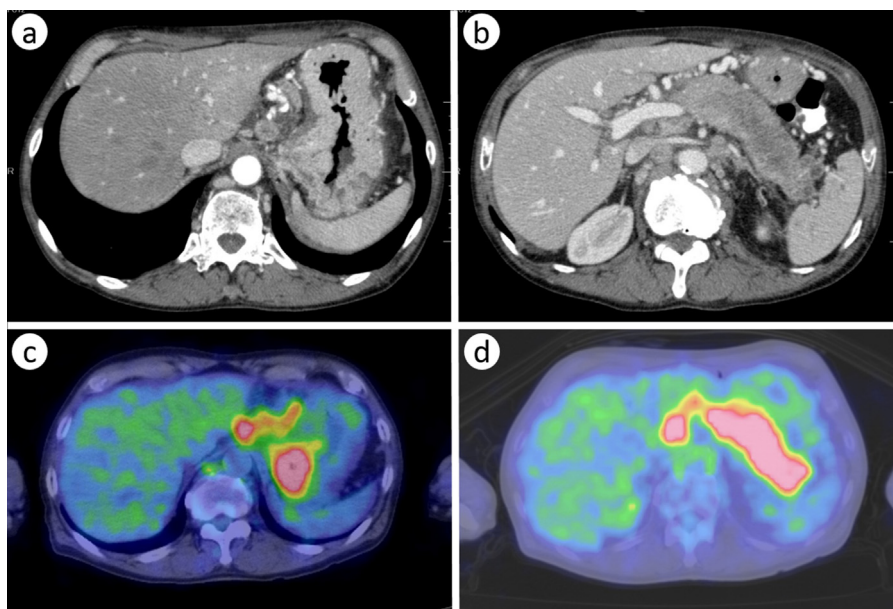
Computed tomography (CT) scan and positron emission tomography–computed tomography (PET–CT) scan using fluorodeoxyglucose (FDG). (a), An abdominal CT scan demonstrated gastric wall thickening with an enlarged perigastric lymph node; (b), An abdominal CT scan demonstrated pancreatic enlargement; (c), A PET–CT scan using FDG demonstrated FDG-avid spots in the stomach and cardiac lymph nodes; (d), PET–CT demonstrated FDG-avid spots in the pancreas.
